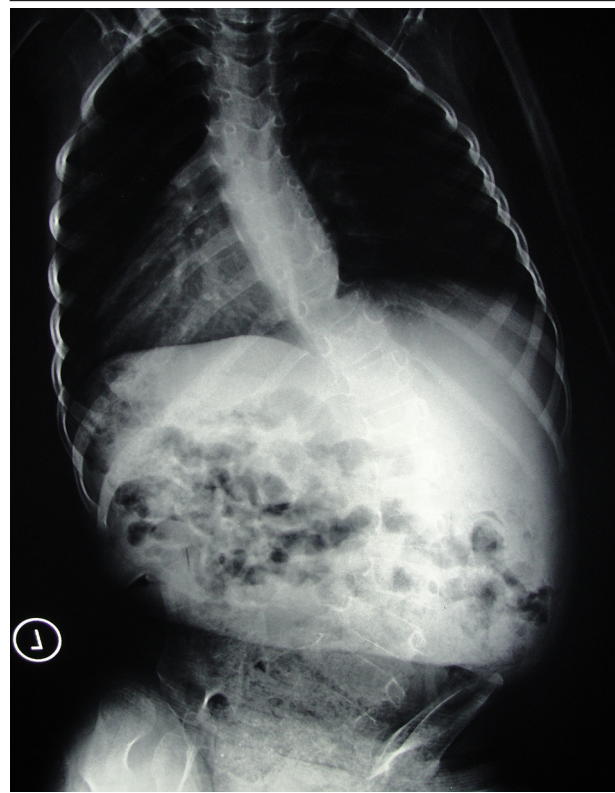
Ap Radiograph of a 8 Year Old Patient With a Neuromuscular Scoliosis Due to None Ambulatory Myelomeningocele
